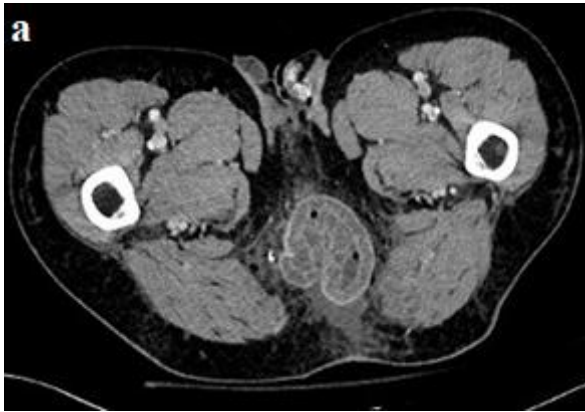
Axial and coronal images of contrast-enhanced CT of abdomen shows herniation of the small bowel loops through a defect in the posterior pelvic floor into the perineum with thickening and increased enhancement of the hernia wall.
